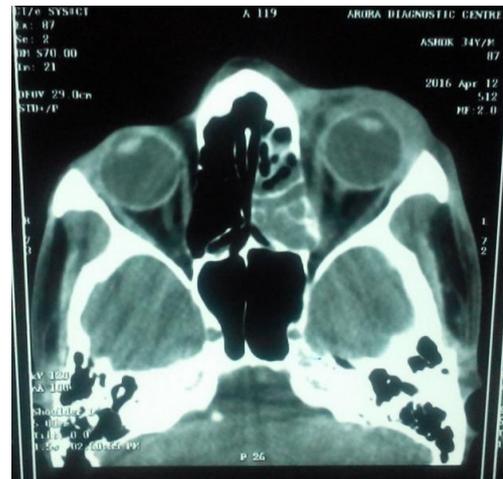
CT scan (Axial section)
